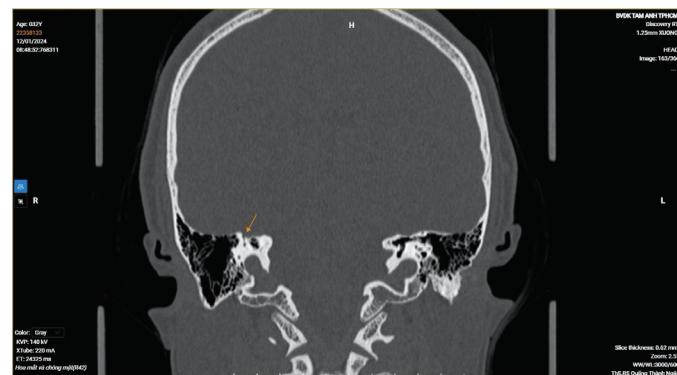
Superior semicircular canal dehiscence. Coronal reconstruction of the temporal bone CT scan in another patient reveals the absence of the bony roof of the superior semicircular canal (arrow).
